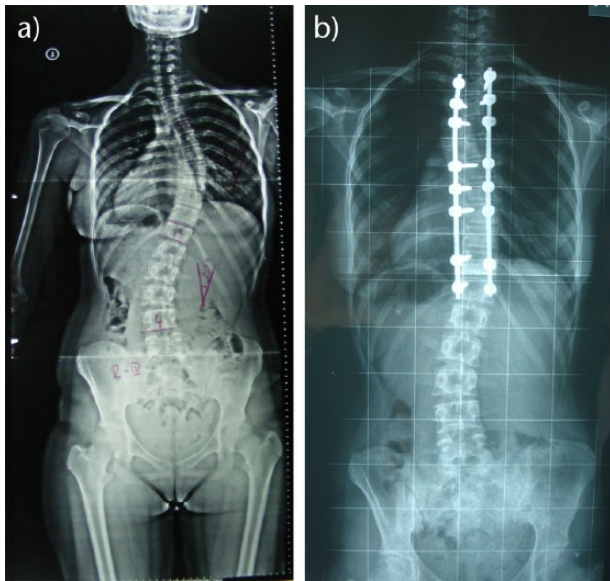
a) Anteroposterior radiograph of a 15-year-old patient with a Lenke Type-1 curve treated with posterior correction and posterior instrumented fusion. b) Post-operative radiograph shows spontaneous correction of the lumbar curve after selective thoracic fusion.
